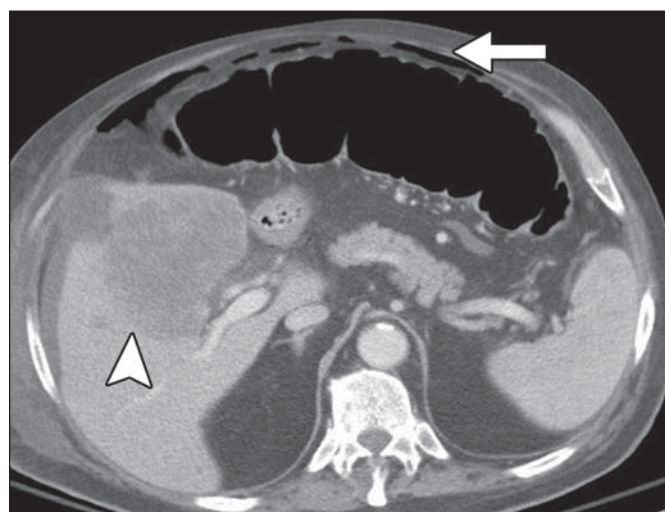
73-year-old man receiving ipilimumab for treatment of metastatic melanoma. Axial CT image of abdomen shows transverse colon (*arrow*) is grossly dilated with free intraperitoneal air, indicating intestinal perforation. Note also large metastasis (*arrowhead*) in right lobe of liver. Patient underwent colectomy, and pathology revealed severe active inflammation consistent with ipilimumab-induced colitis.
